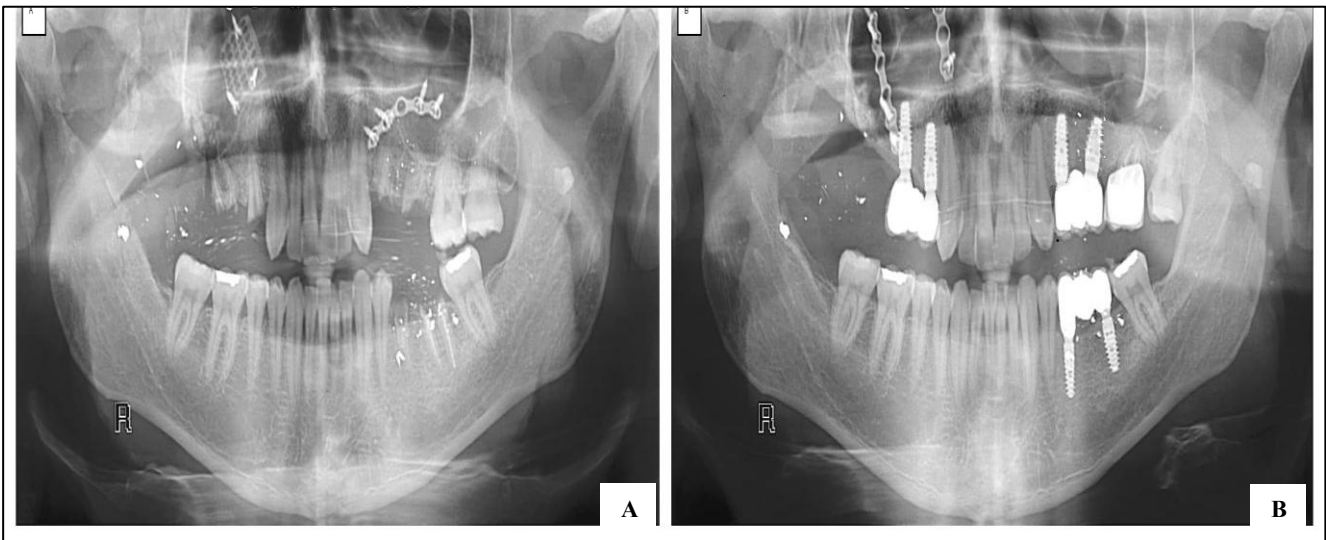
Panoramic radiographs: (A) before corrective surgery; (B) after completion of treatment demonstrating healed maxilla and implant-supported rehabilitation.
